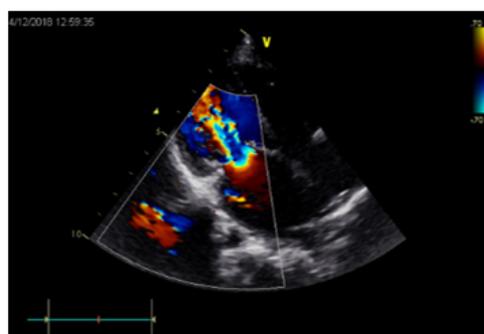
2-D Color Doppler Apical view TTE view in diastole showing the obstruction caused by the SMR. MV: Mitral Valve.
